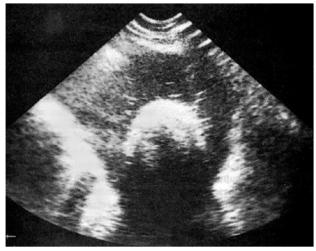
Ultrasound showing a pelvic mass.
